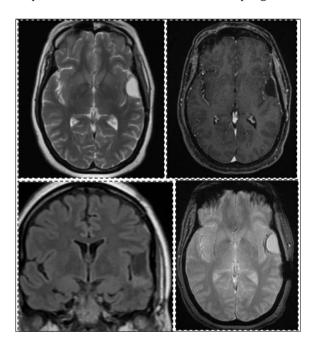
Post operative follows up MRI at 12 months showing no residual lesion
